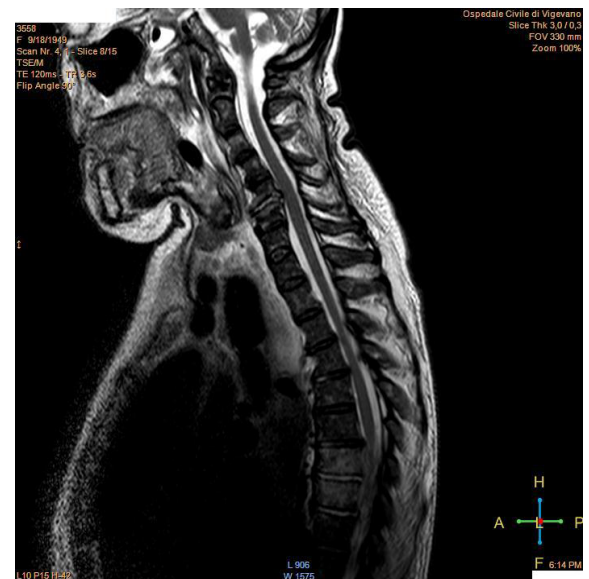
MRI sagittal cut showing hyperintense and inhomogeneous signal in cervical and dorsal tracts during empiric antibiotic therapy.
